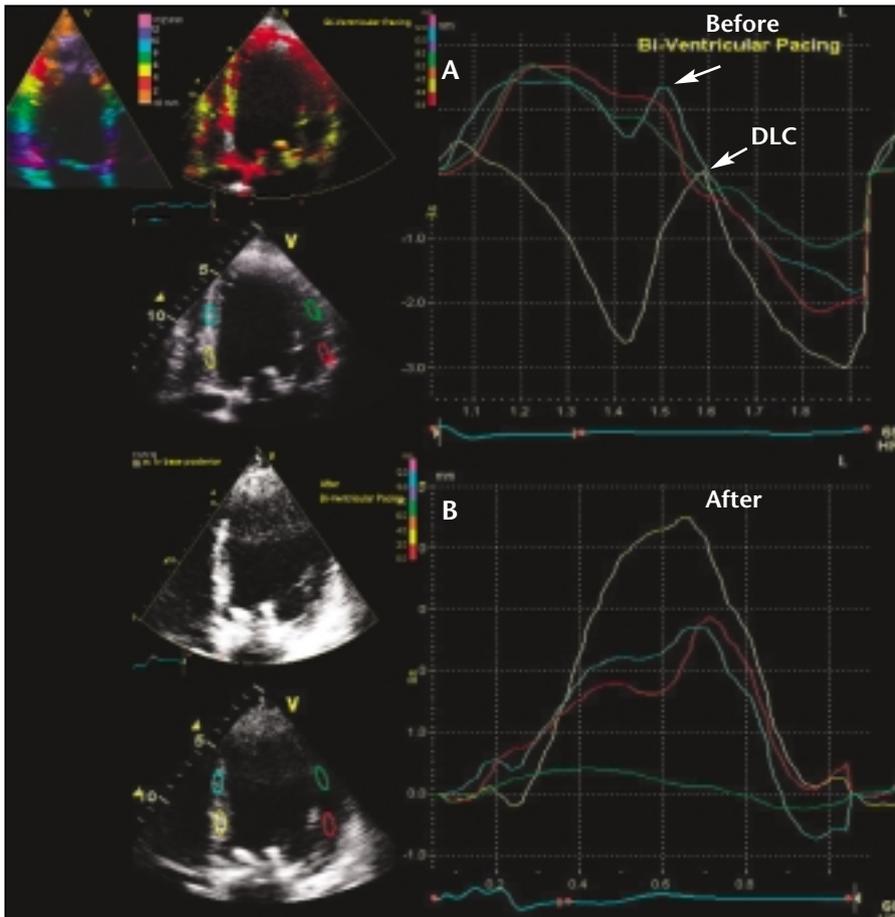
Q-tissue tracking analysis before (A) and after (B) bi-ventricular pacing. Tissue tracking images in apical 4-chamber views and placement of sample volumes in the left ventricular lateral wall and interventricular septum are shown at the left. Tissue velocity curves with colors representing motion of segments selected are on the right. Note presence of delayed longitudinal contraction (DLC) in the basal and mid-interventricular septum, which disappears after cardiac resynchronization therapy (CRT). Color encoding on the left represents tissue displacement. Red and yellow colors represent longitudinal displacement of 4-6 mm and purple represents tissue displacement of >12 mm. Three chamber view showing normal tissue tracking velocities are shown on the left for comparison. Note diffuse decreased longitudinal displacement velocities before CRT.
